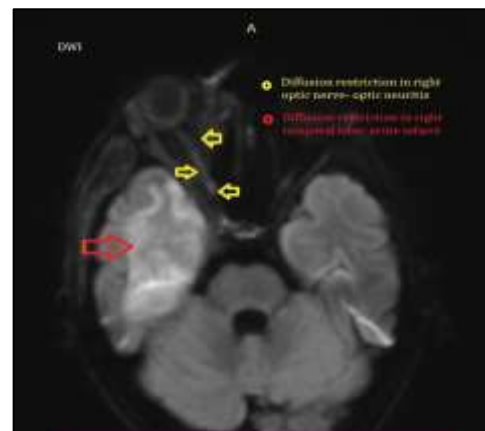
DWI axial section showing restriction in right optic nerve-optic neuritis (multiple small yellow arrows) and right temporal lobe-acute infarct (red arrow).
